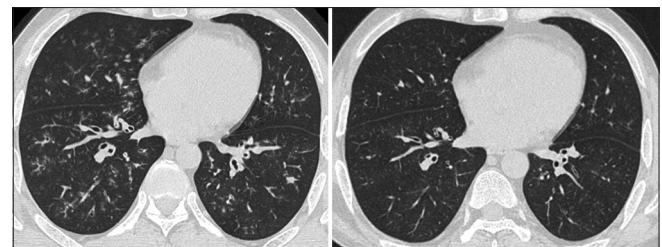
Axial images taken a year apart show resolving ground-glass opacities and centrilobular nodules in the follow-up CT images (a) image in 2019, (b) image in 2020. CT: computed tomography, arrow: tree-in-bud sign, arrowhead: centrilobular nodules
